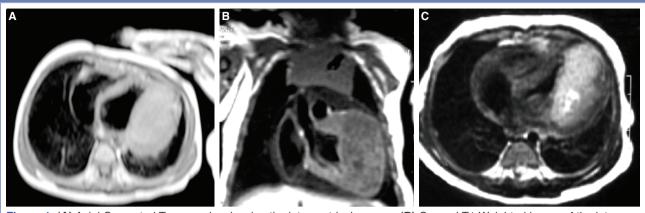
(A) Axial Computed Tomography showing the intraventricular mass. (B) Coronal T1 Weighted image of the intraventricular mass isointense to the myocardium. (C) Axial Gradient magnetic resonance image showing the mass isointense to the myocardium.
